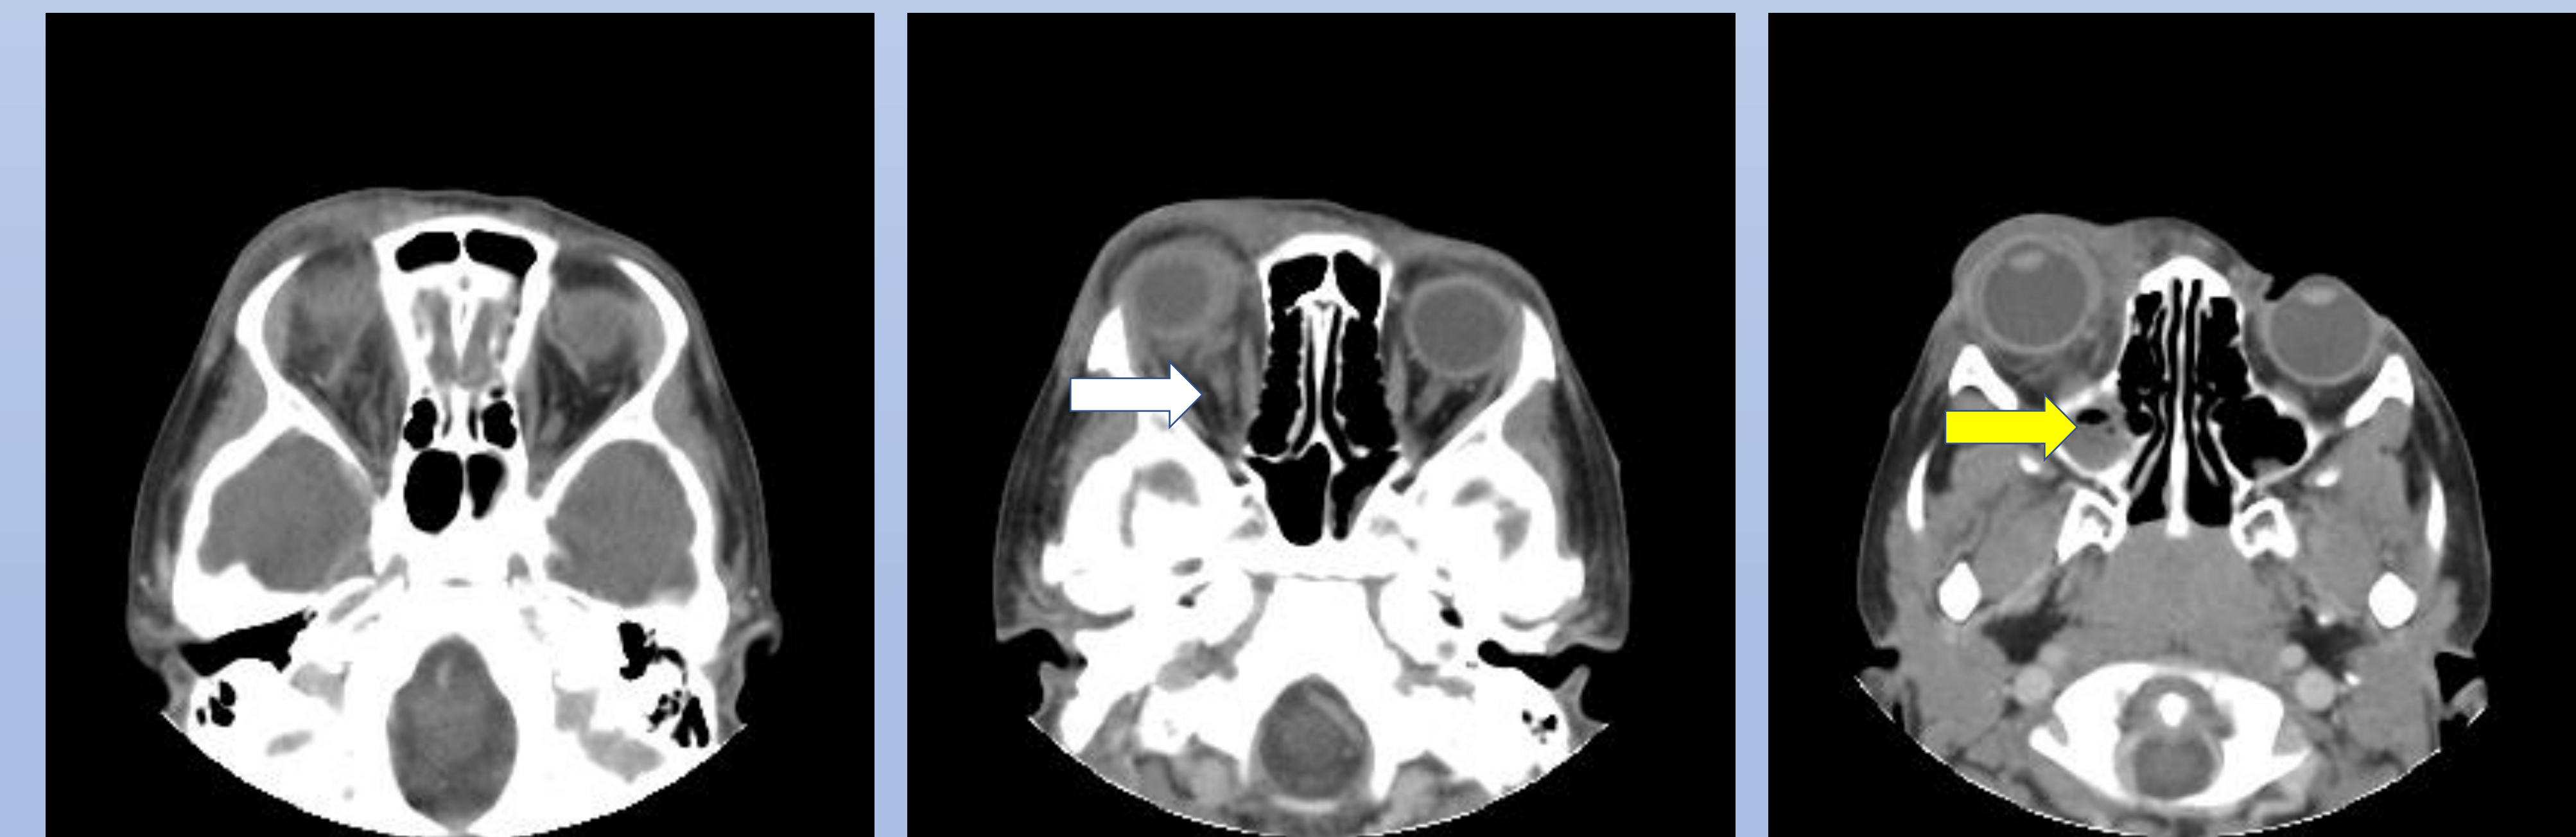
CT scan showing inflammatory changes within the retro-orbital fat and dilation of the right superior ophthalmic vein (white arrow). Extensive right maxillary sinus disease was also found (yellow arrow). The ethmoidal and frontal sinuses were clear
